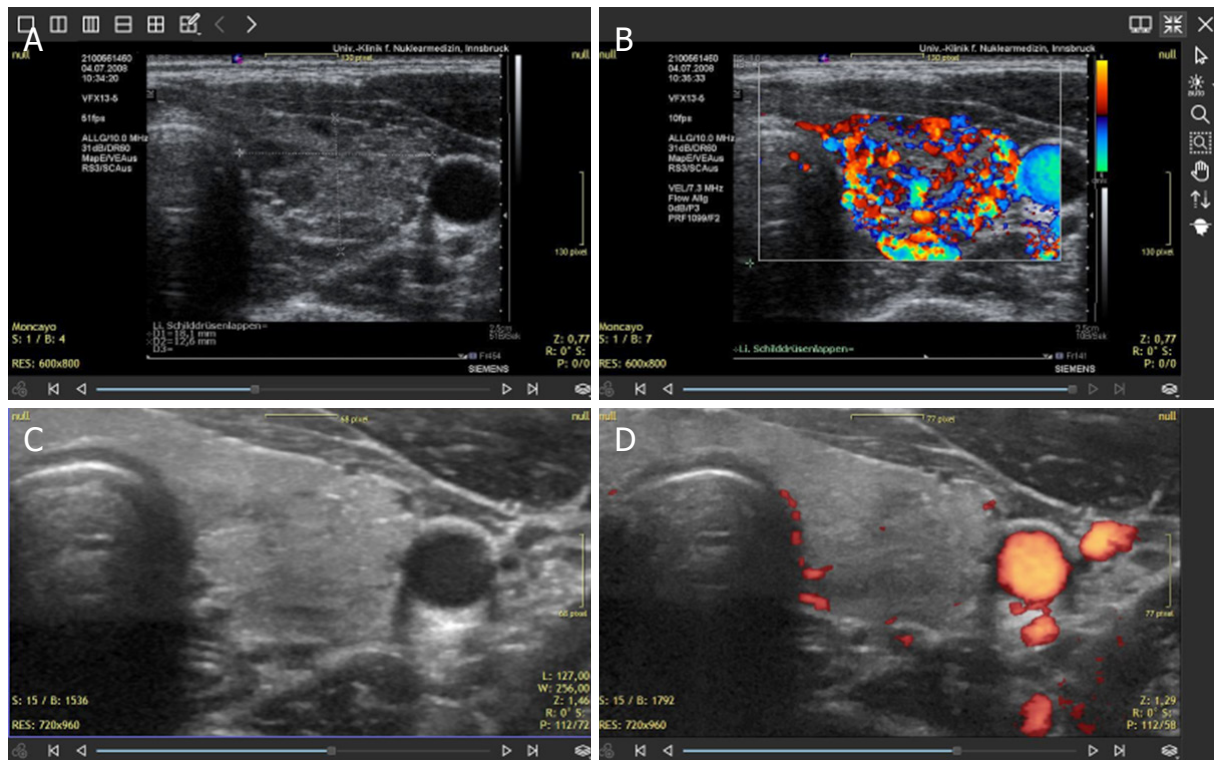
The Index Case showing combined deficiencies of magnesium, selenium, and CoQ₁₀. Thyroid sonography was done using 2 different systems: SIEMENS Antares in 2008 (A, B) and GE LOGIQ E9 in 2019 (C, D). In 2009, the thyroid showed diminished echogenicity and hyperperfusion as seen in color mode. The images C and D demonstrate the improvement of thyroid morphology together with a normalization of perfusion. These changes disappeared after combined supplementation was started. Currently the patient does not require any thyroid medication
